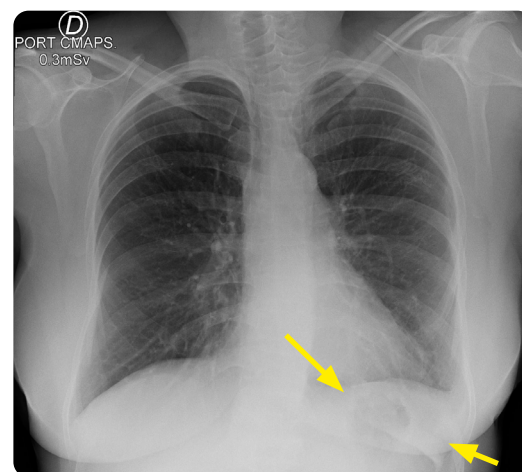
Chest X-ray, PA projection. As an incidental finding, there is a dense calcified image of triangular appearance in the region of the left hypochondrium, compatible with the splenic silhouette.
